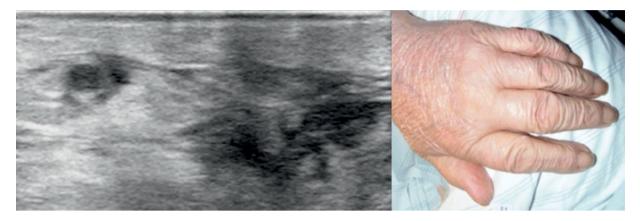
Ultrasound imaging of the dorsal hand prior to steroids of a pt (case 1) with PMR diagnosed retrospectively (top). Dramatic response on a short course steroid therapy with remaining folds (bottom)
